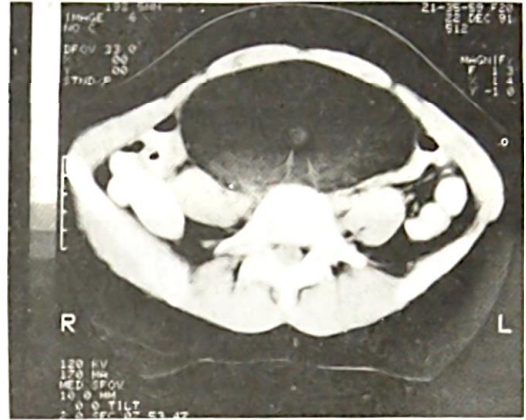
(Case 4): CT scan showing a fat-fluid interface. A dermoid plug circumscribed by fat is seen in the centre of the lesion (arrow), the "target" sign. (Ultrasound scan same case as Fig. 3: Note that no fluid level was seen on ultrasound scan).
